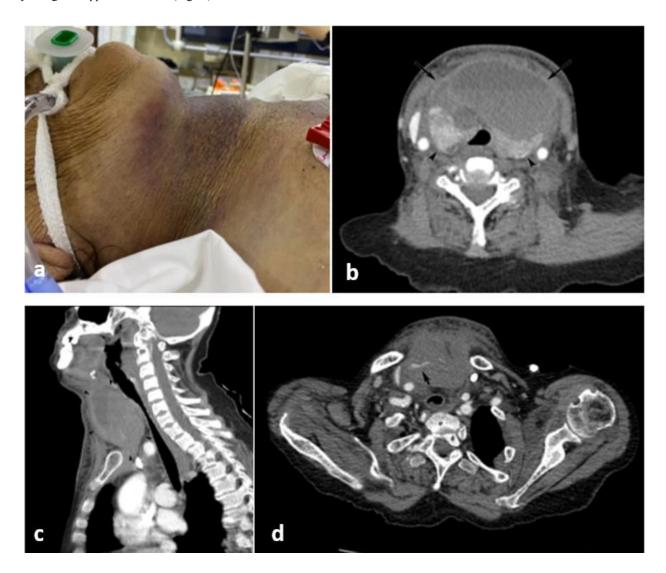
(a). Widespread swelling and ecchymosis in the neck (b). A large hematoma (arrowhead) anterior to the thyroid gland (arrow), The trachea, and both internal jugular veins appear compressed (c). Large hematoma (arrowheads) and tracheal compression. (d). Active extravasation on CTA (arrow).
